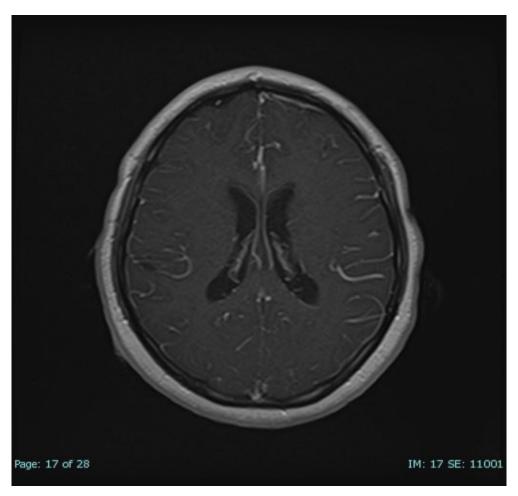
T1-weighted image with contrast revealing diffuse leptomeningeal enhancement.
